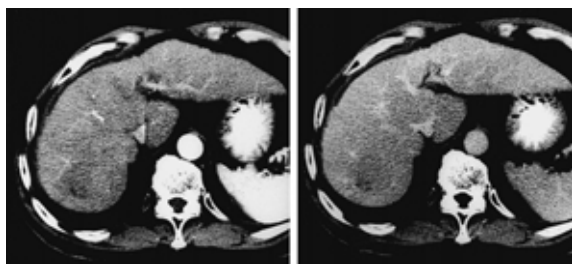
Case 6. An early conventional CT image (left side) and a CT image taken seven minutes later (right side)
